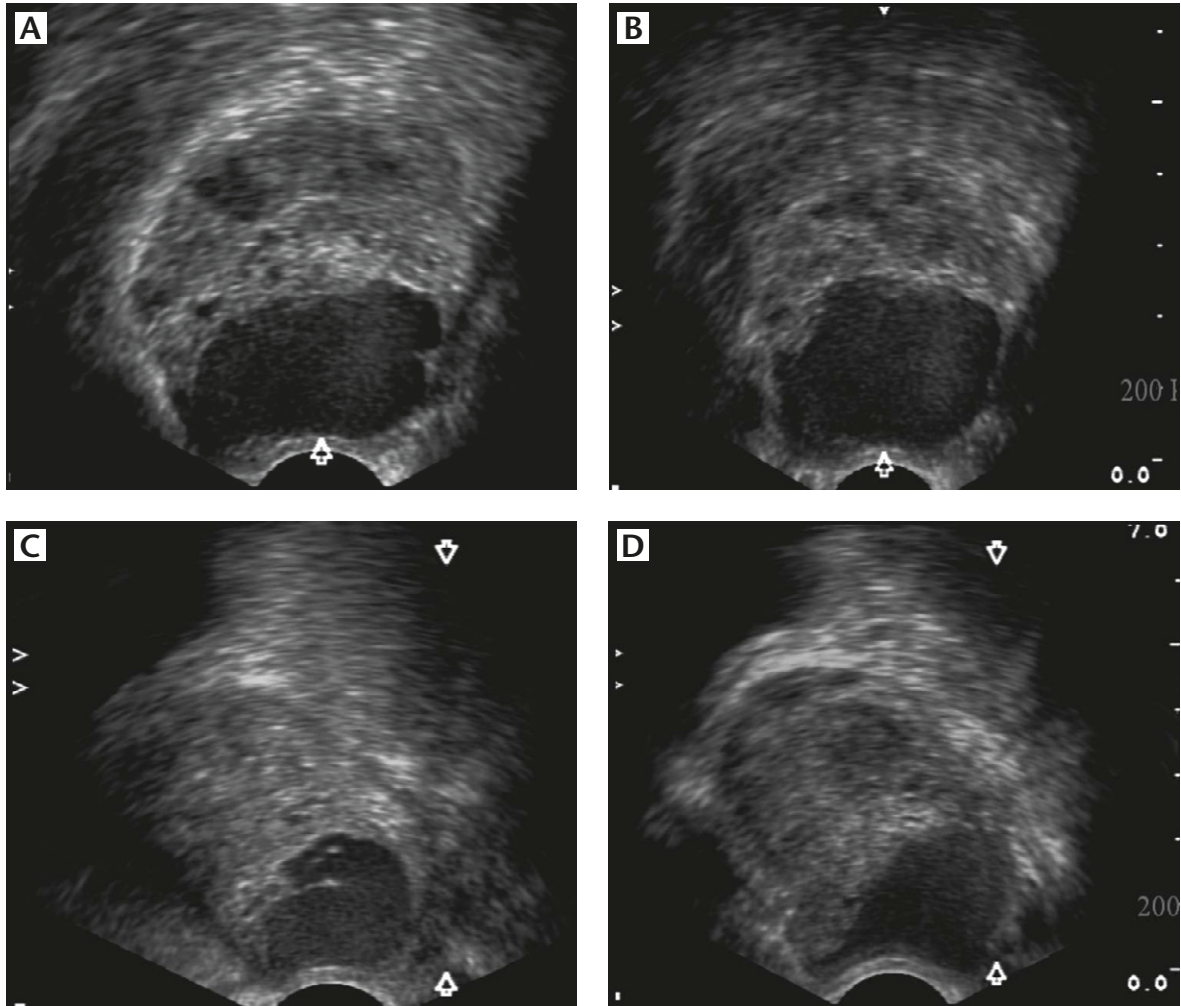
Transrectal sonography revealed a cystic lesion over the apical portion of the prostate with a size of 2.0 cm × 3.1 cm × 3.9 cm. (A) mid-transverse view. (B) Apical-transverse view. (C) Right sagittal view. (D) Left sagittal view. There was a low echoic content within the cyst and several scattered hypoechoic lesions in solid portion of the prostate.
